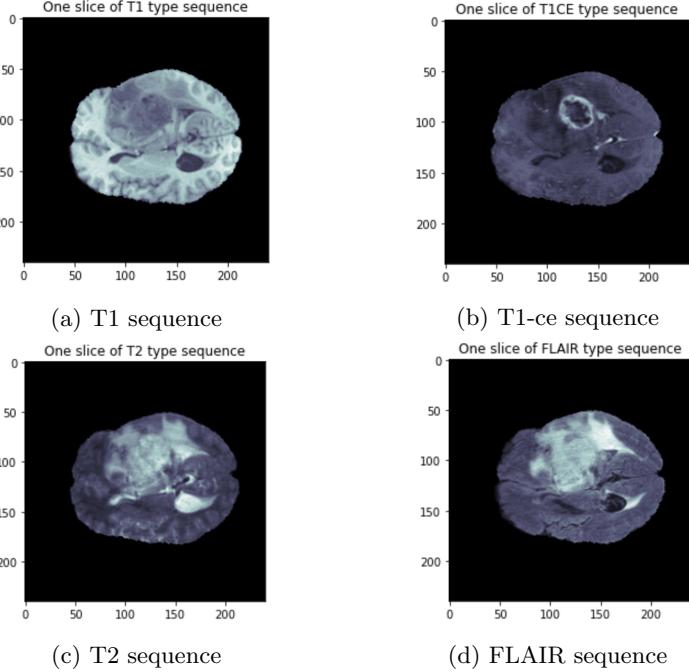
One slice of T1, T1ce, T2, FLAIR sequences each of size 240×240
